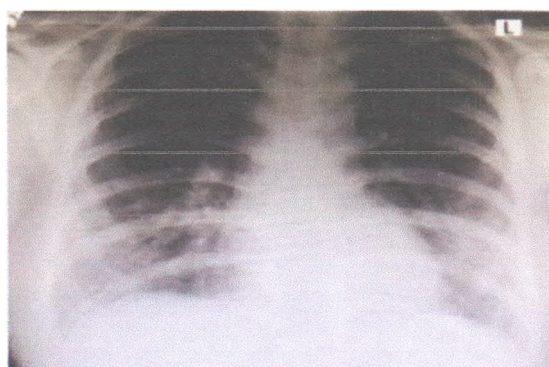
Chest x-ray of patient Day 14.
